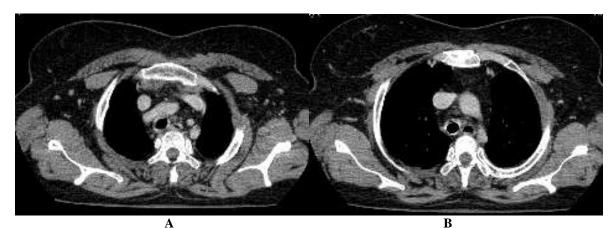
CT scan sections of the thoracic CT control.
